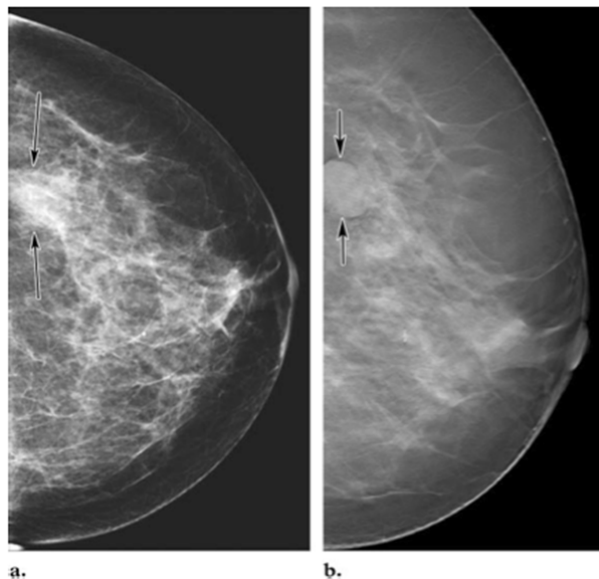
(a) Mammogram and (b) tomosynthesis image of a benign breast mass (arrows) demonstrating enhanced visibility in the latter. Reproduced, with permission, from Park JM, Franken EA, Garg M, Fajardo, LL, Niklason, LT. Breast tomosynthesis: Present considerations and future applications. Radiographics, 2007, vol 27 Suppl. 1, pages S231–40.
